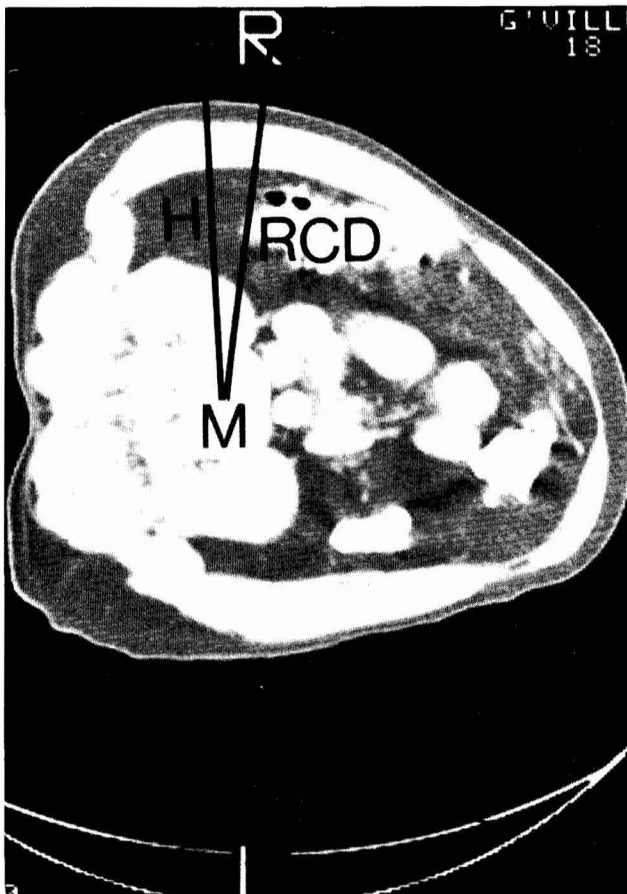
Abdominal CT scan in the surgical position of a patient acceptable for PD. Note that the dorsal border of the bowel is ventral to Line H. (See Table 1 for definition of labels.)
